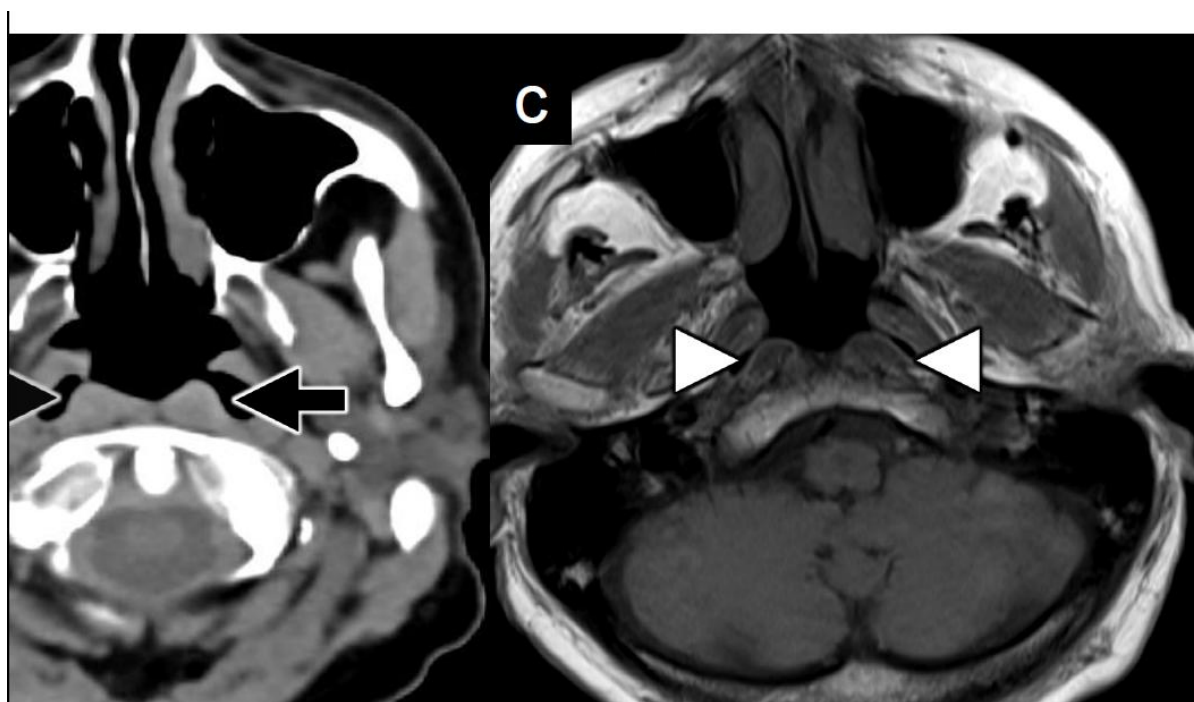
Involuntary muscular activity with FDG uptake. Fused axial PET/CT (a) shows symmetric increased FDG uptake along the posterior wall of the nasopharynx (white arrows). Axial NECT (b) shows corresponding normal appearance of the longus colli (black arrows), which is confirmed on (c) axial T1-weighted MRI (white arrowheads).
